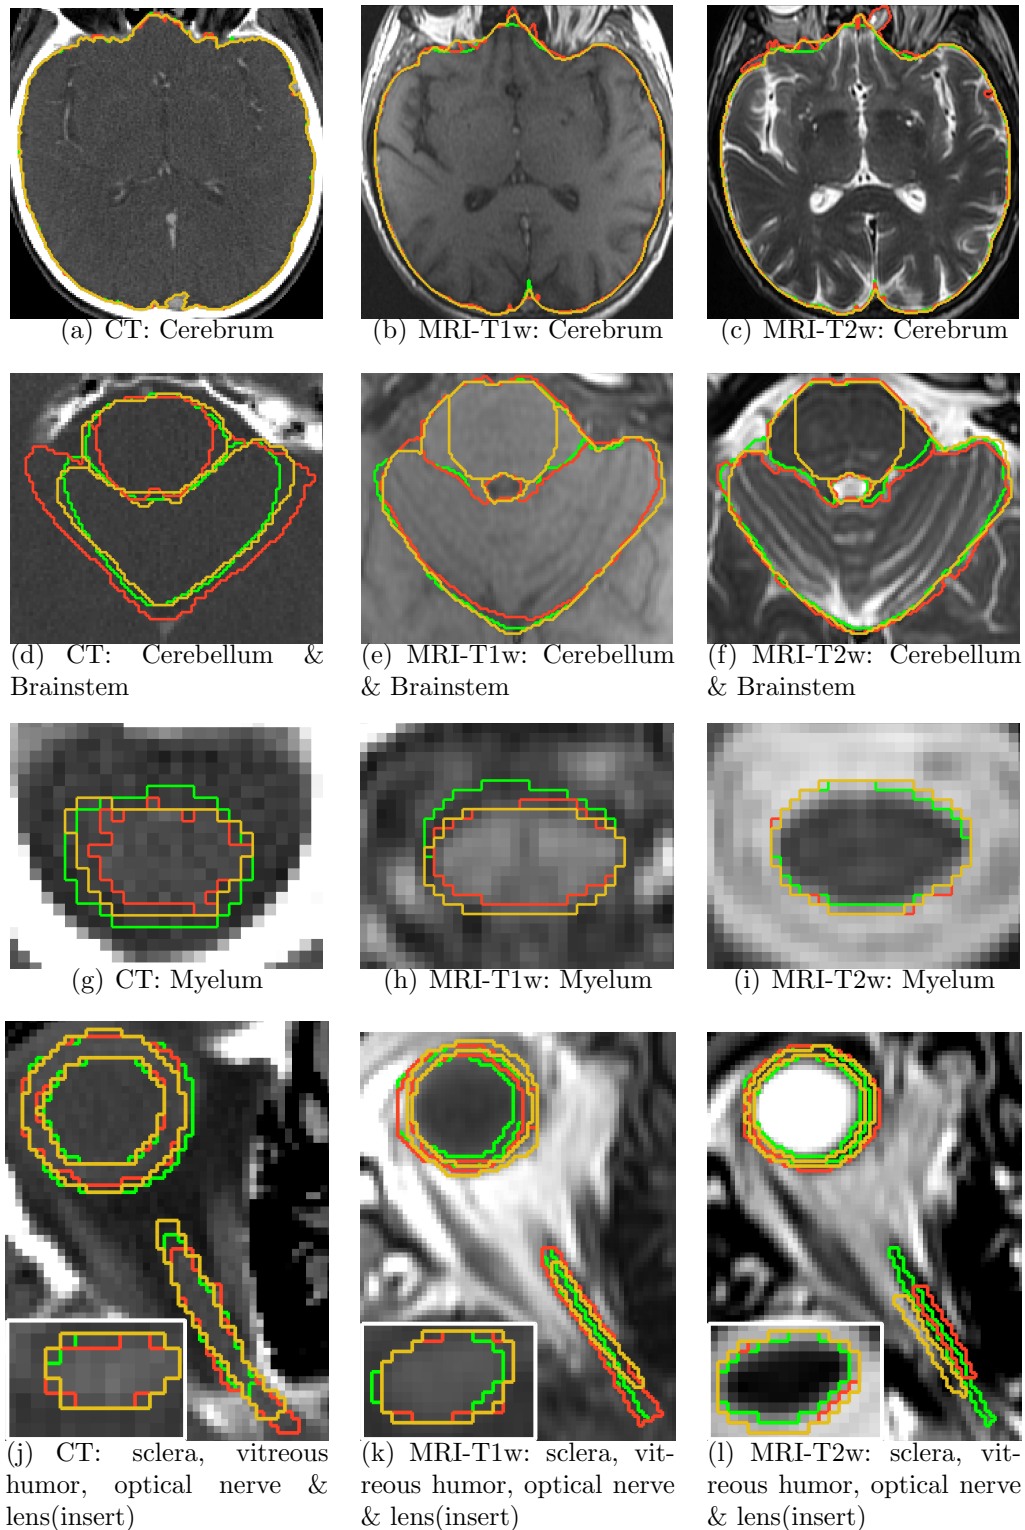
Example of manual segmentations on CT, MRI-T1w and MRI-T2w images for cerebrum (a-c), cerebellum and brainstem (d-f), myelum (g-i) and for sclera, vitreous humor, optical nerve and lens (j-l). The colors indicate the segmentation of each observer: observer 1 (green), observer 2 (red), observer 3 (yellow).
